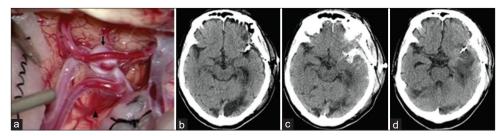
Case 1 (a) During surgical clipping for an aneurysm (arrow) of the left middle cerebral artery, a thin and pial artery bleeds slightly at 1 point of the left frontal lobe (arrowheads), and hemostasis is easily achieved using cotton. (b) Computed tomography (CT) 19 h after surgery shows no evidence of intracranial hemorrhage. (c) CT 36 h after restarting apixaban (24 h after discontinuing the heparin-DOAC bridge) shows subarachnoid hemorrhage in the left Sylvian fissure. (d) CT 240 h after surgery shows no additional increase of the hematoma.
